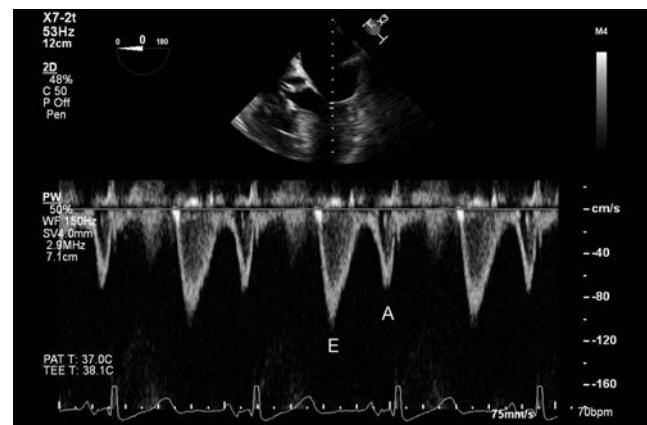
Transmitral pulsed-wave Doppler profile demonstrating the peak early filling (E-wave) and flow due to atrial contraction (A-wave).
